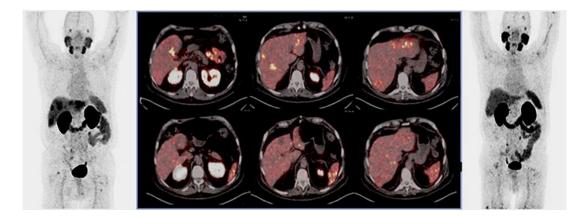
Ga-68-PSMA PET/CT with multifocal liver metastases in castrate-resistant prostate cancer (top row) and after successful treatment with 2.5 GBq Y-90 microspheres (bottom row) demonstrating almost complete disappearance of PSMA-positive liver metastases
